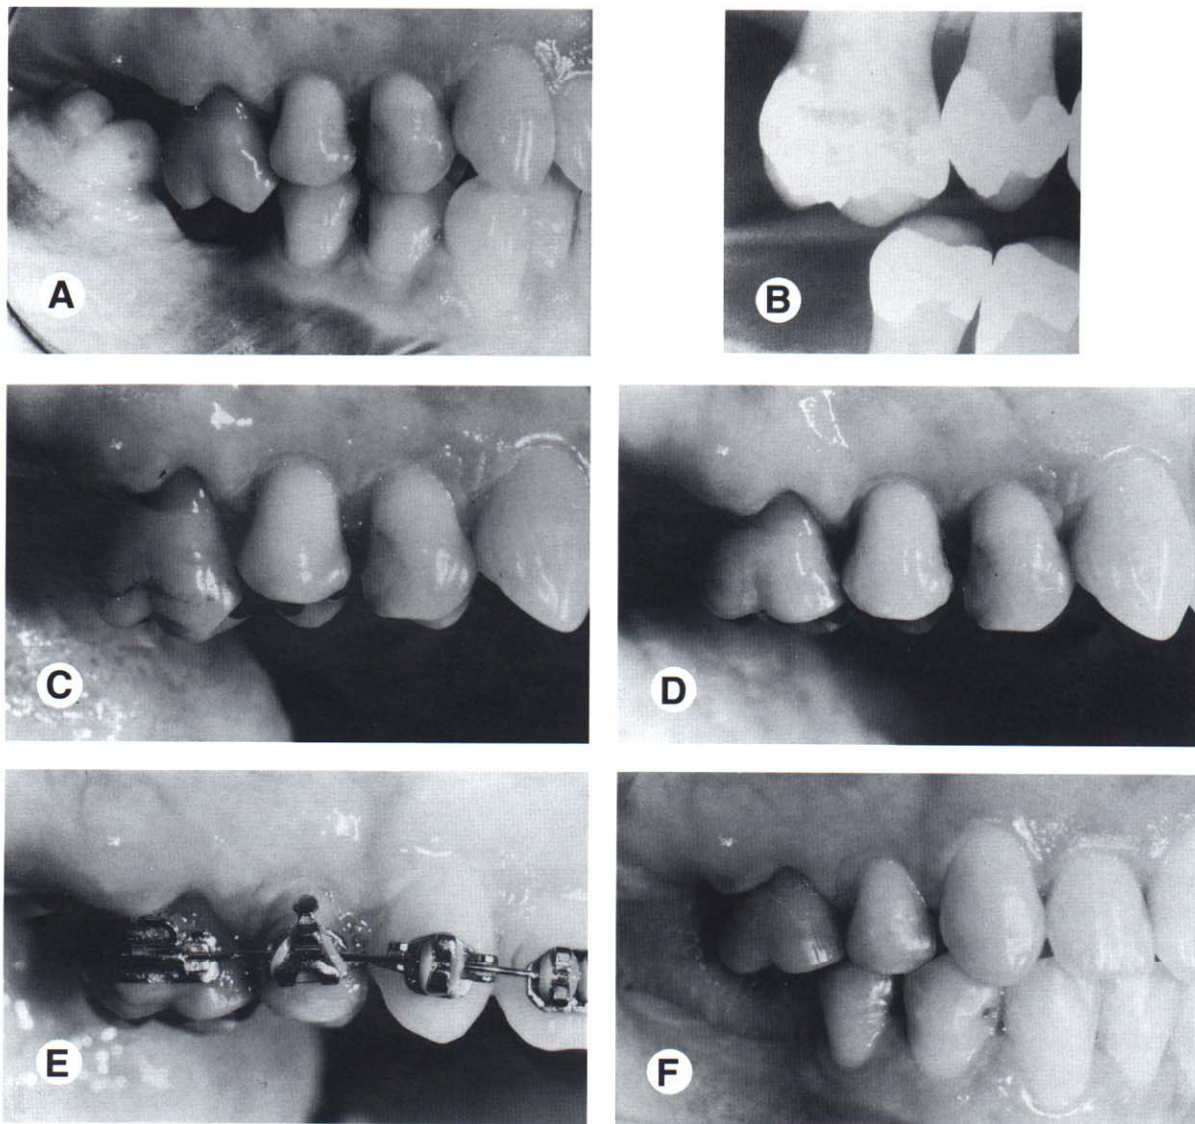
This patient showed overeruption of the maxillary right first molar and a marginal ridge defect between the second premolar and first molar (A). A pretreatment periapical radiograph (B) showed that the interproximal bone was flat. To avoid creating a hemiseptal defect, the occlusal surface of the first molar was equilibrated (C and D) and the malocclusion was corrected orthodontically (E and F).
